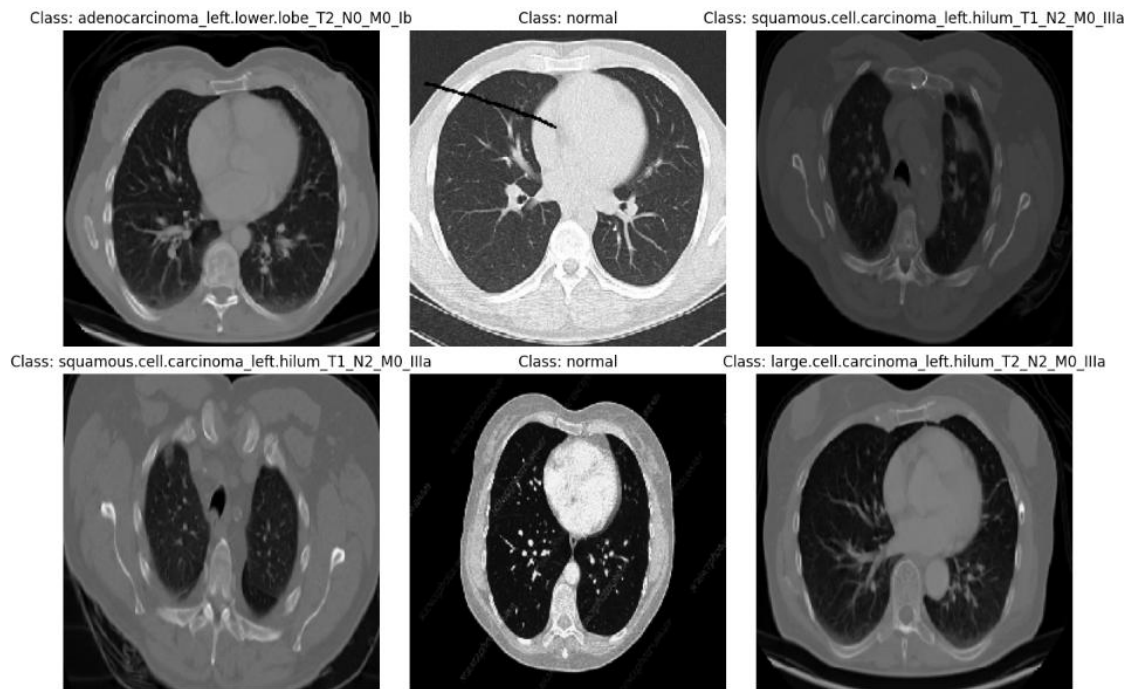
Sample CT Images from Training Dataset After Preprocessing and Visualisation
